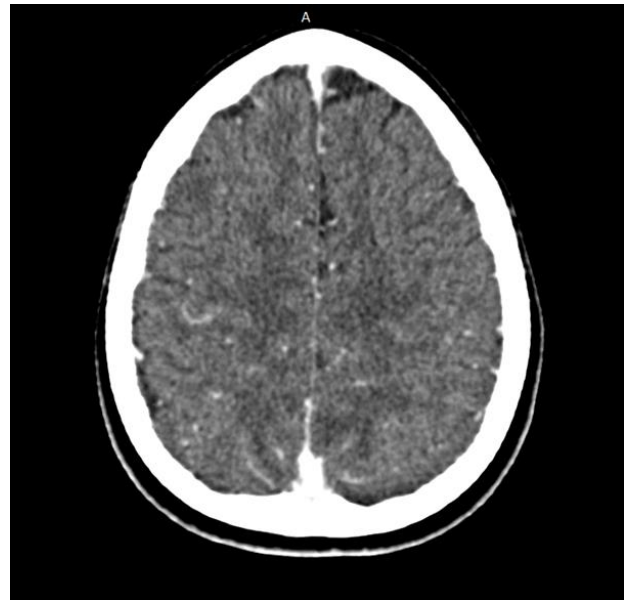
Axial view contrasted CT Brain (reprinted with permission of the patient)
